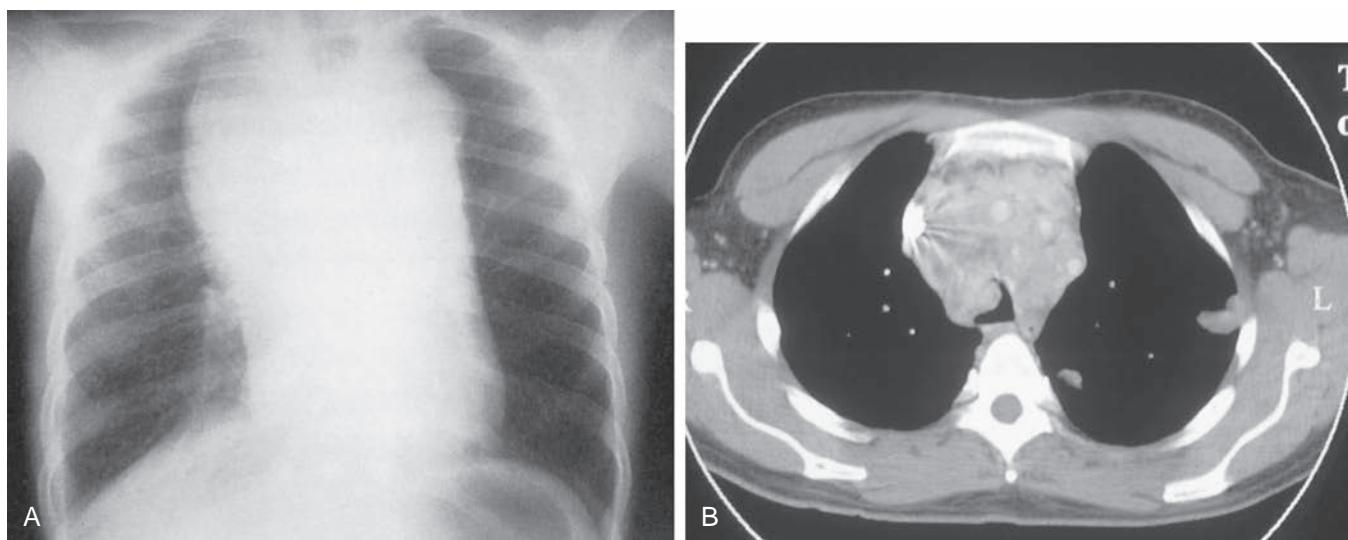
(A) Chest radiograph of an adult patient with an anterosuperior mediastinal mass. This mass was a lymphoma. (B) A thoracic computed tomographic scan with contrast just above the level of the carina shows partial compression of the carina and right mainstem bronchus. This patient has an "Uncertain" distal airway (see text).
